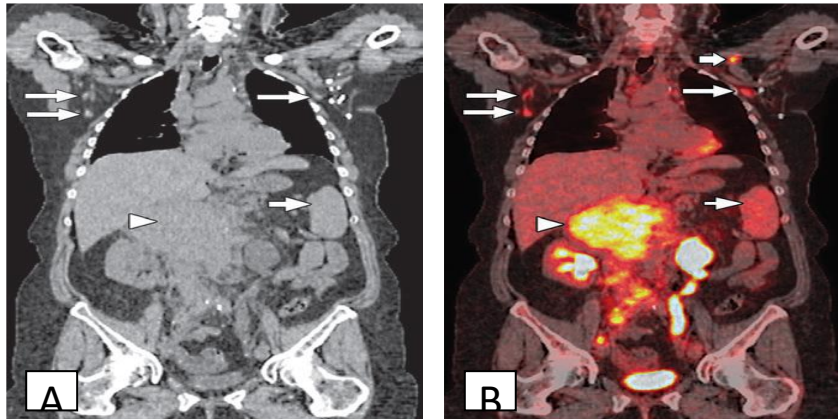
3-year-old woman with follicular lymphoma newly diagnosed after biopsy of retroperitoneal mass. (Baseline staging with PET/CT). A, Coronal CT image shows large retroperitoneal mass consistent with known site of biopsy proven lymphoma (arrowhead). Also present are indeterminate subcentimeter lymph nodes in axillae (long arrows). Spleen (short arrow) is of normal size. At CT, mass was considered stage II, representing involvement of more than one lymph node station on one side of diaphragm. B, Coronal fused PET/CT image shows intense  $^{18}\text{F}$ -FDG uptake by retroperitoneal mass (arrowhead) and abnormal  $^{18}\text{F}$ -FDG uptake in small axillary lymph nodes (long arrows). Unexpected  $^{18}\text{F}$ -avid lymph node (thick short arrow) was found in left infraclavicular region. Diffuse intermediate-grade  $^{18}\text{F}$ -FDG uptake in spleen (thin short arrow) greater than that in liver is considered to represent diffuse lymphomatous infiltration. Disease severity was increased to stage IIIS. (11).
